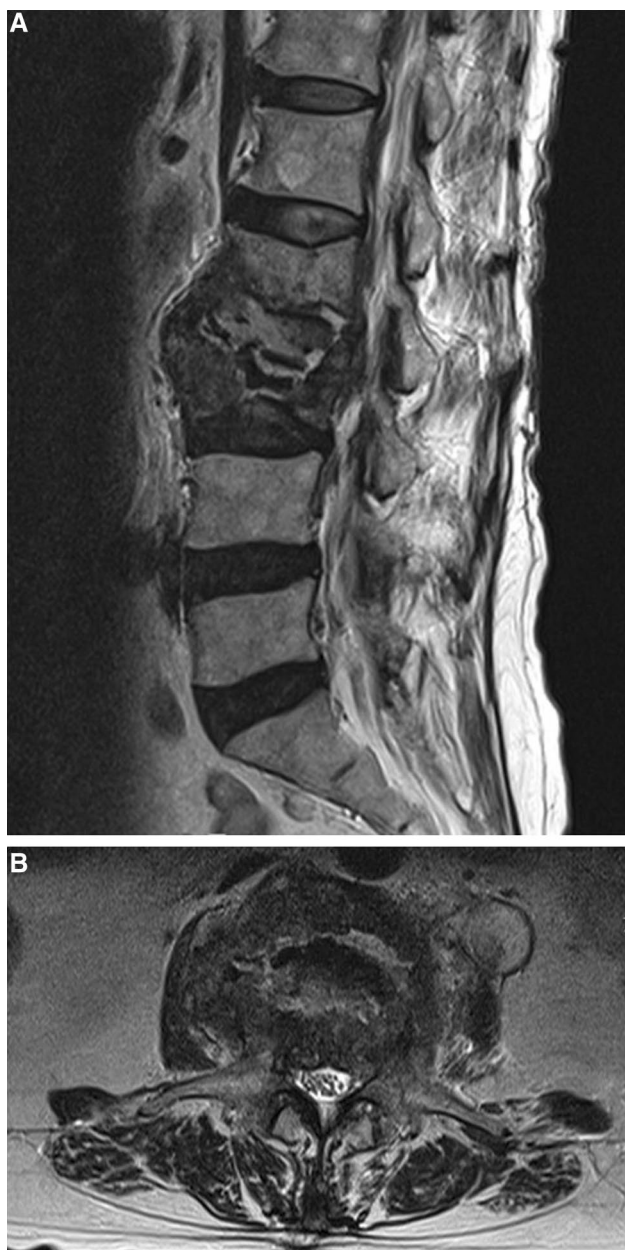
a Sagittal and b transversal T2 magnetic resonance images revealed L2 and 3 spondylitis with a left-sided psoas abscess and L2/3 discitis
